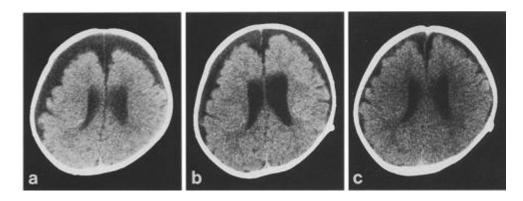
shows a series of CT scans: a) Before the operation, b) 7 days after the operation, c) 32 days after the operation.
